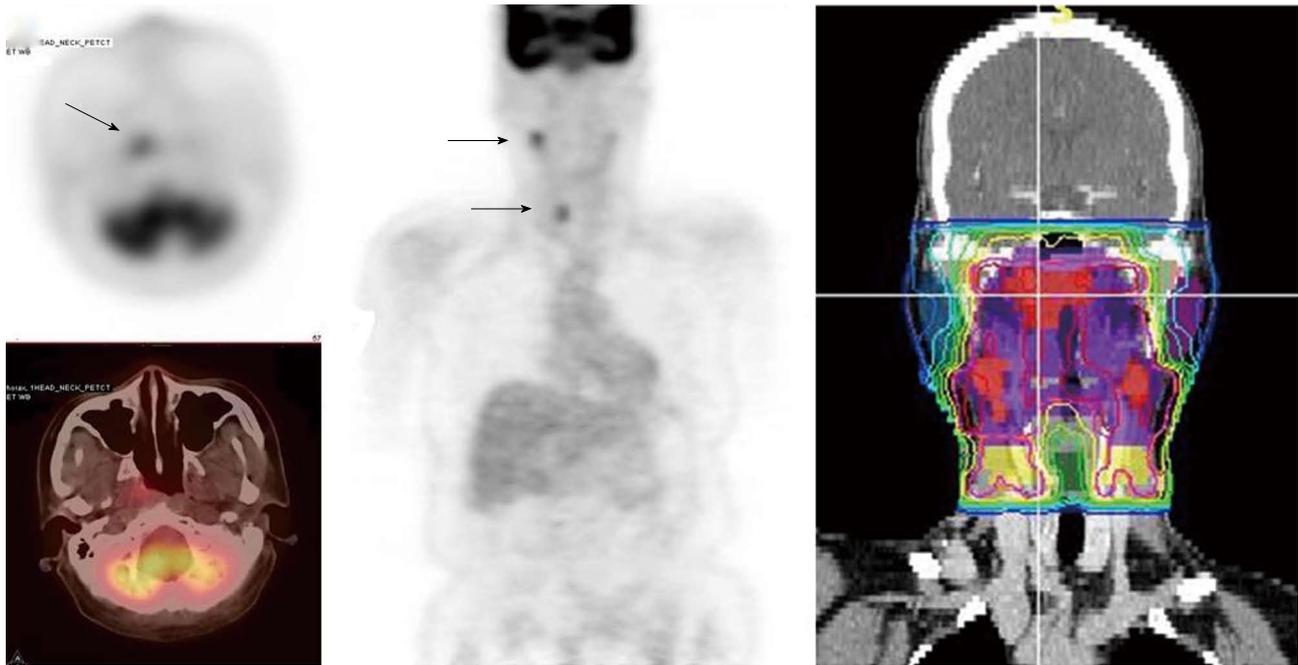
A patient with nasopharyngeal cancer. A: Initial stage was T1N0 when the patient was referred to our institution after conventional workup (arrow in axial image); B: Fluorodeoxyglucose positron emission tomography revealed hypermetabolic foci in the primary tumor in the nasopharynx and in bilateral level II lymph nodes which were small and were not called as lymphadenopathy in her computed tomography and magnetic resonance imaging. Fine needle biopsies of these lymph nodes were obtained. The right level II node (arrows) was confirmed to contain metastatic disease, while the left level II lymph node was not diagnostic; C: Intensity modulated radiotherapy plan for this patient. The right level II node was treated to a high dose of radiation. The lower neck was treated with an anterior-posterior field (From Woods C, Sohn J, Machtay M, Yao M. Radiation treatment planning for head and neck cancer with PET. *PET Clinics* 2012; 7: 396; with permission).
